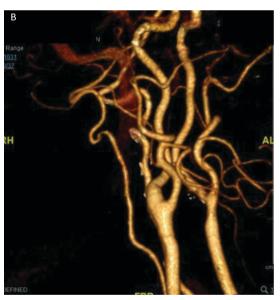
(A,B) Post-operative CT with 3D Recon showing complete plaque removal.
